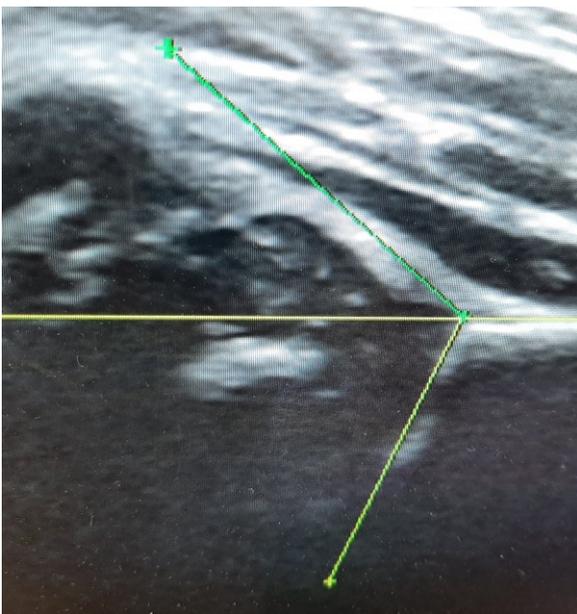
Hip Ultrasound for new-born
